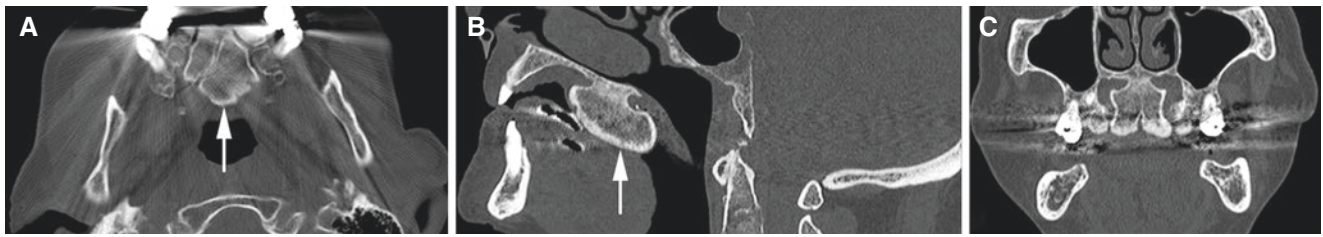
Torus palatinus; 84-year-old male, incidental finding. (A) Axial, (B) sagittal, and (C) coronal CT images show bony outgrowth in the midline of the hard palate (*arrow*)
